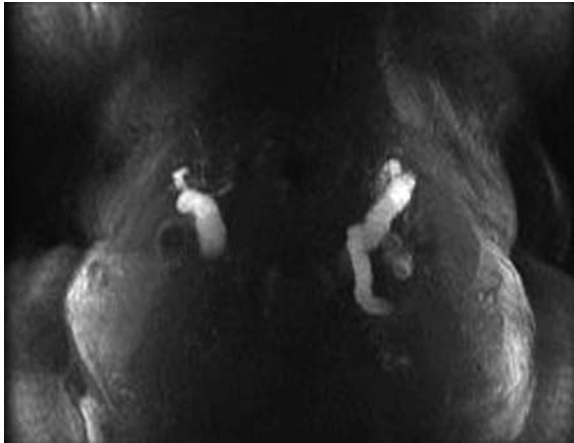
MRI: from the top projection
